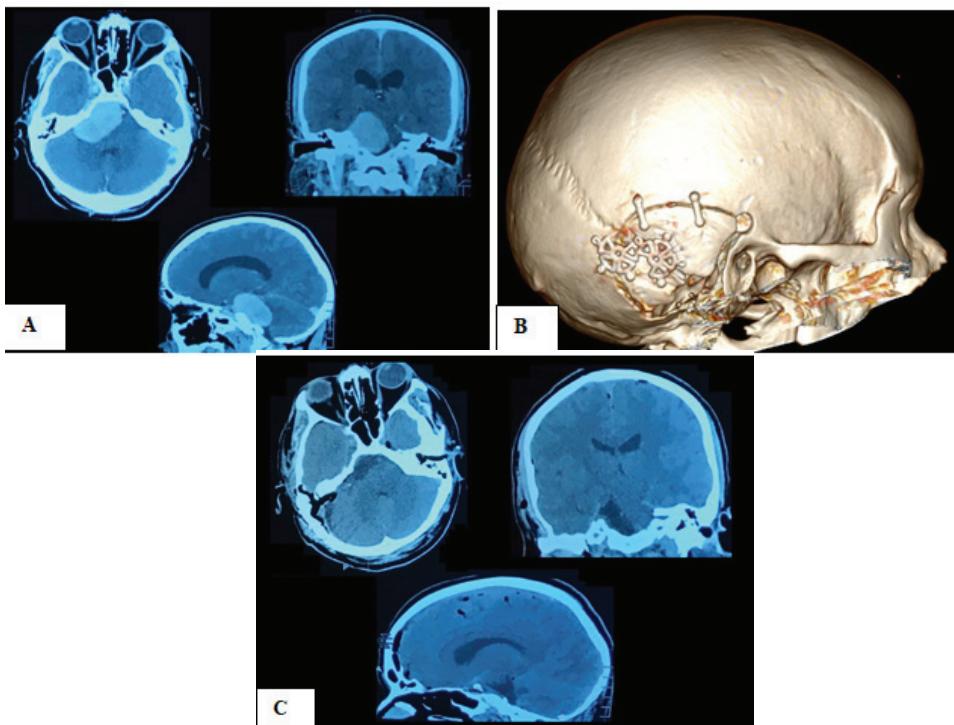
Petroclival meningioma, 44x30x42 mm (MRI preop - Fig. 1A).
